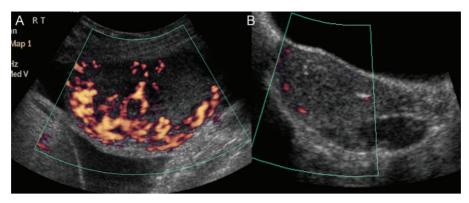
Pelvic Doppler ultrasonography of persisting GTN following a HM. (A) Pre-chemotherapy. (B) Post-chemotherapy. (Reprinted from ref. [1], Copyright 2010, with permission from Elsevier.)
